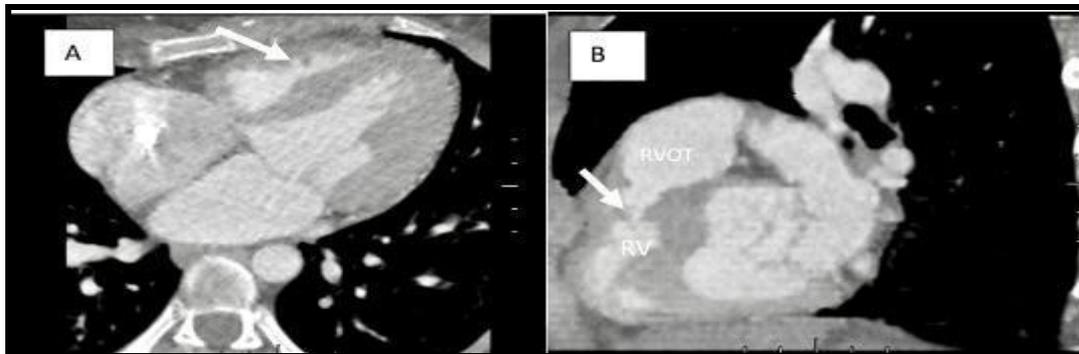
Cardiac CT in DCRV. Panels A and B demonstrate axial and sagittal views respectively, on CTA. The arrows demarcate an AMB crossing from the interventricular septum to the RV free wall, consistent with DCRV.
